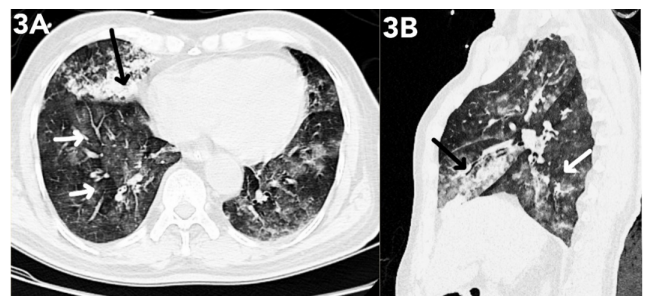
CT Thorax follow up (both 3A & 3B) revealed mildly decreased density of alveolar hemorrhage (white arrows) and evolving right middle lobe consolidation (black arrows). (Images taken from the department of radiology, KMCH)
